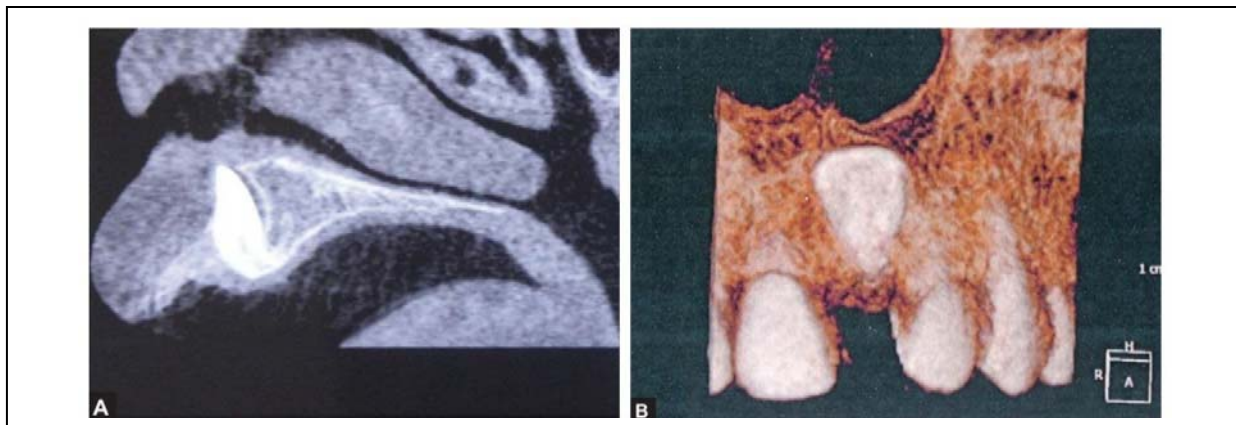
(a) : Sagittal section of cone beam computed tomography image showing an impacted tooth root located palatally with a large part close to palatal cortical bone, (b) three dimensional frontal photographic reconstruction from CBCT image of a patient with maxillary left permanent central incisor dilaceration (Pwanjit et al., 2016).
